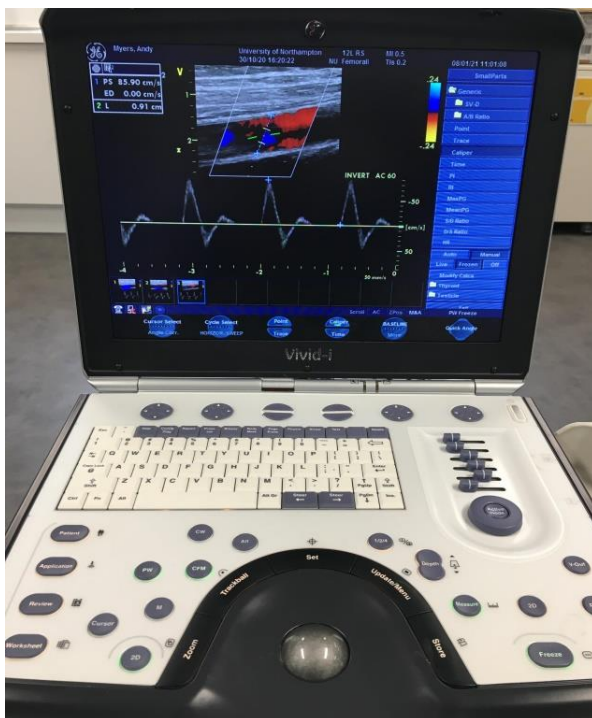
Vivid I ultrasound machine to assess femoral artery diameters and blood velocities. Image displayed in pulse wave mode.
